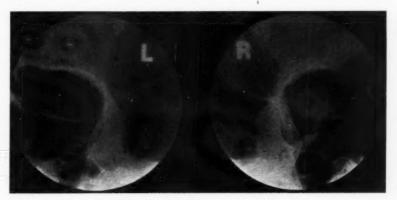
(Pfeiffer). Case 6. Meningioma of inner third of sphenoid ridge (inset). Roentgenogram showing the hyperostosis involving the lesser wing of the sphenoid of the right orbit, together with thickening of the lateral wall of the orbit adjacent to the superior orbital fissure.
